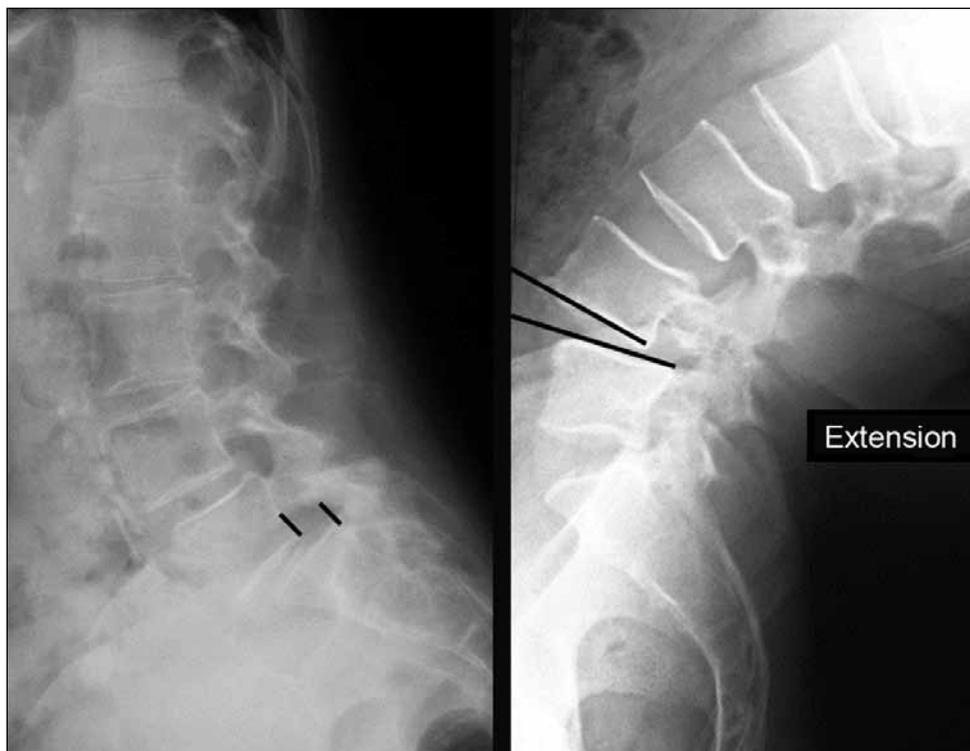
Measurements of functional X-ray studies disclose anterior or posterior translation and angulation of vertebra.
